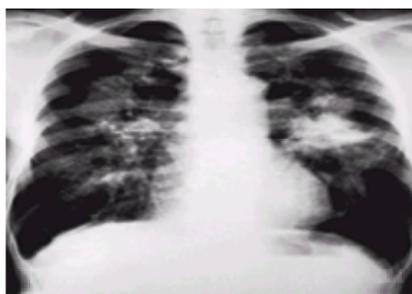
Radiograph of a subject with stage C complicated CWP.
